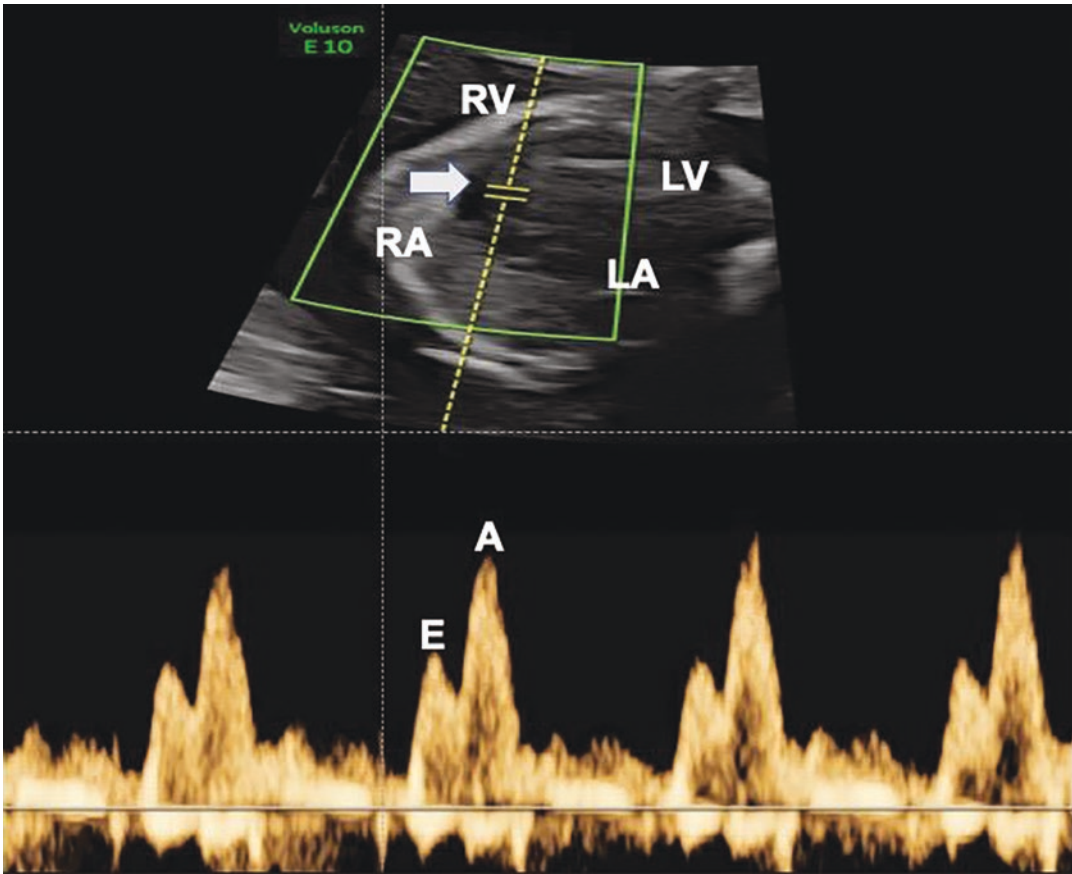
Doppler imaging of the tricuspid flow in the first trimester of pregnancy is depicted here. The upper panel shows two-dimensional echocardiography of an apical four-chamber view of the fetal heart at 13 weeks' gestation. The horizontal arrow indicates the Doppler sampling location. Note the optimal alignment of the ultrasound beam path with the flow direction (vertical
